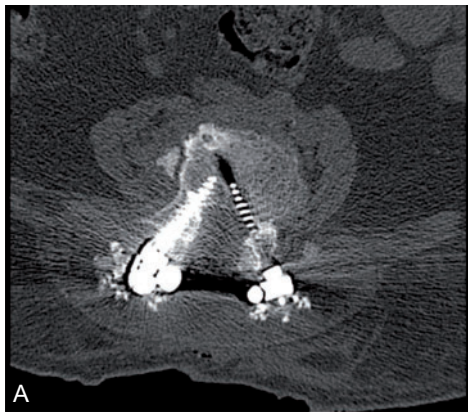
(A) Axial CT slice showing normal anatomic insertion of both screws in vertebral bone in a severely osteoporotic and rheumatoid patient. (B) The endplate extrusion of the right-side screw (arrow) was visualized by multi-slice CT.
